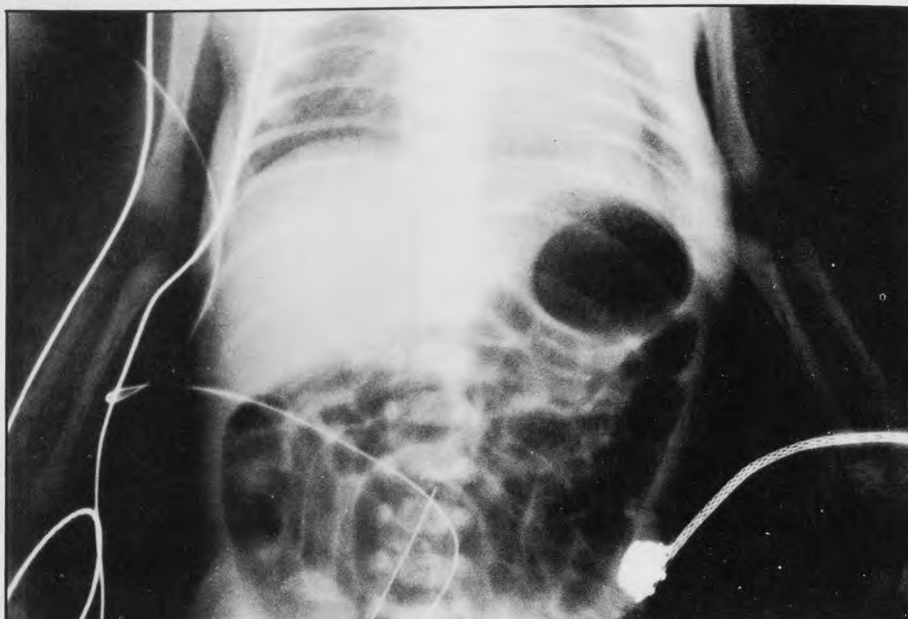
Anteroposterior roentgenogram showing lower aortic umbilical catheter between lumbar vertebrae 3 and 4
